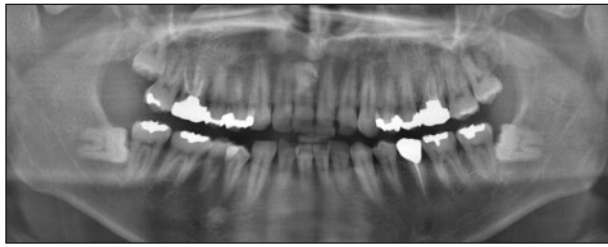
(above) Panoramic radiograph revealing no dental caries, periodontitis, or intrabony lesions.
